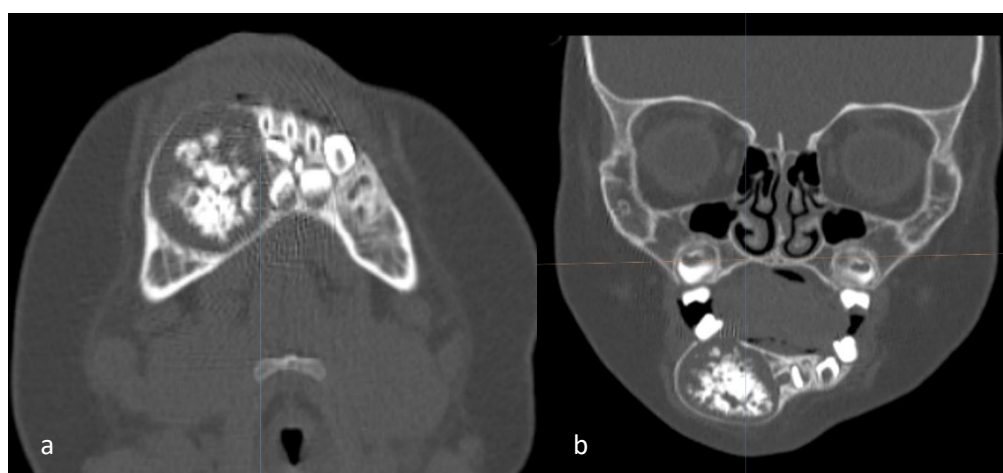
(a) Axial view of the lesion in CT; and (b) Coronal view of the lesion in CT
